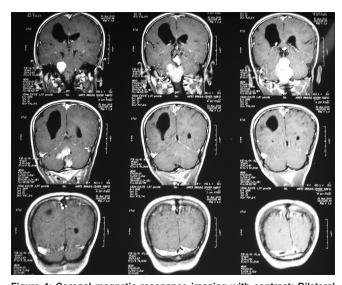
Coronal magnetic resonance imaging with contrast: Bilateral acoustic neuroma, and meningioma
